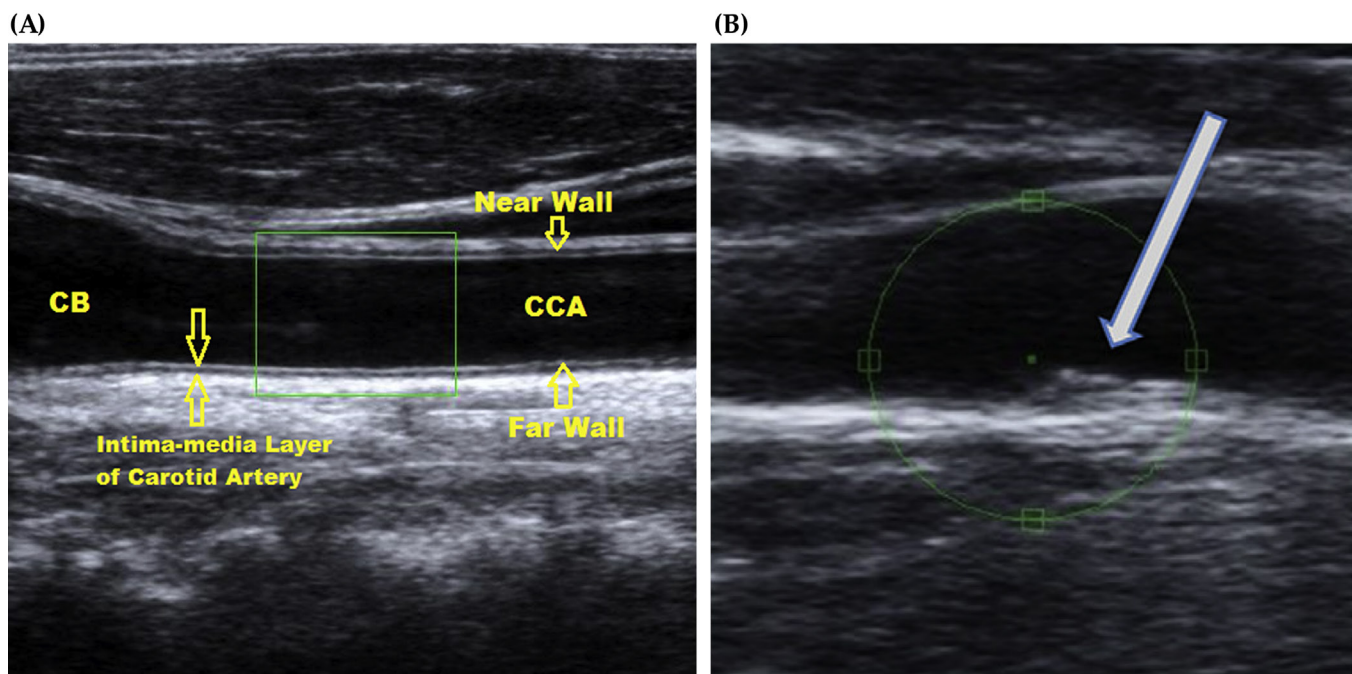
Ultrasonographic evaluation of the carotid artery for IMT: (A) Doppler ultrasound scan of the common carotid artery (CCA) and carotid bulb (CB). Measurement of the carotid intima-media thickness is taken in the far wall 1 cm from the CB, demonstrating the characteristic finding of the “double echo” marking the intima-media complex. Adapted from the personal collection of Dr. A. Sandoo, Bangor University, Bangor, Wales, UK. Occasionally, a vascular atherosclerotic plaque is found, marking more progressive vascular involvement (B, arrow). Adapted from Dalla Pozza et al. [102].
